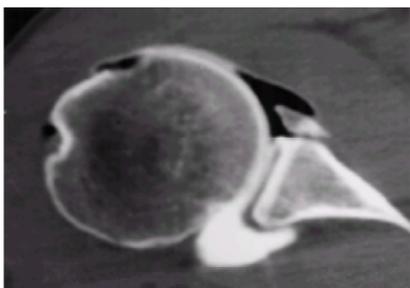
CT arthrogram following trauma. The appearances are almost identical to those seen in [Fig. 55](#). There is avulsion of the anterior lip of the labrum and the underlying corner of the glenoid.
